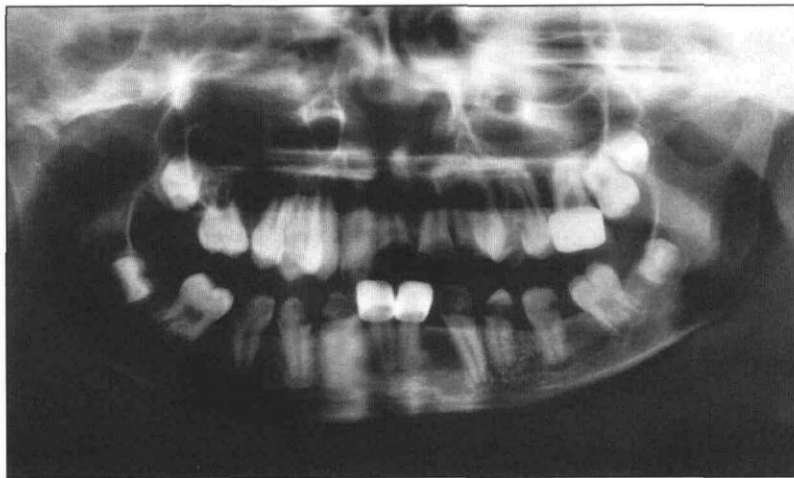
Rampant caries and multiple cervical lesions are evident in this radiograph of a 13-year-old with severe EBDR.
